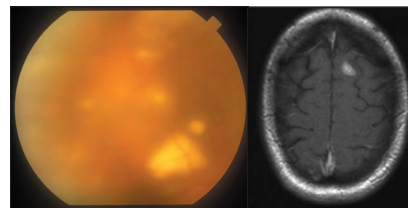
Non-Hodgkin’s lymphoma of the CNS (intraocular large cell lymphoma). a. Fundus photograph shows multifocal yellowish subretinal pigment epithelial infiltrates, the hazy view is the result of marked vitritis. b. Magnetic resonance image of the brain shows a discrete intracranial tumour nodule.
